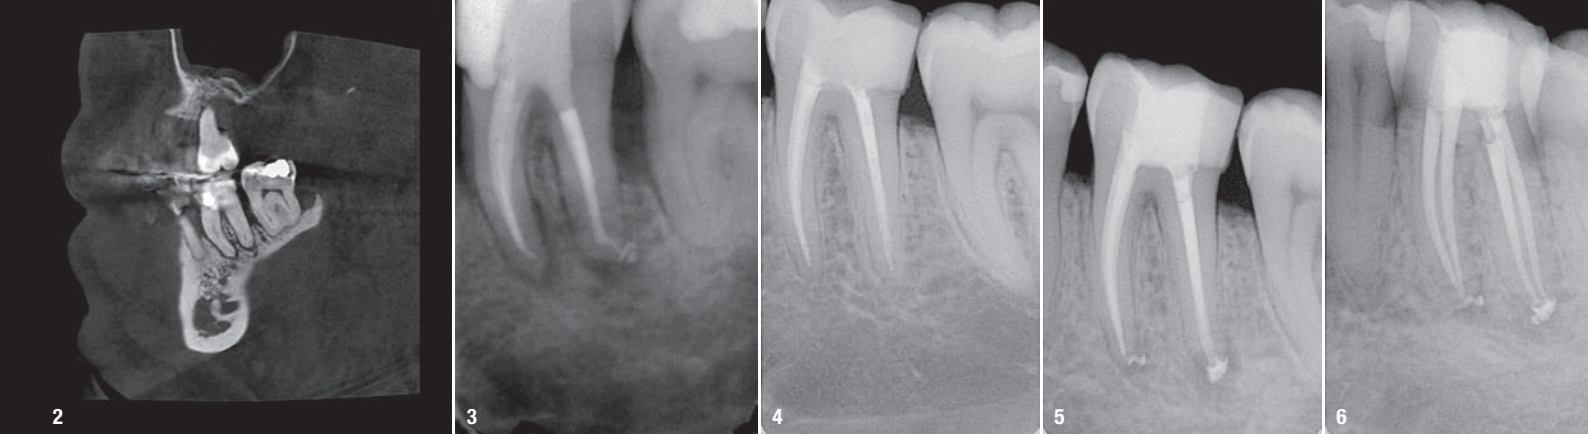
Pre-op radiographic image of tooth #37 (Case 1). (Image: © Dr Thomas Rieger) Fig.3: Post-op radiographic. (Image: © Dr Thomas Rieger)
